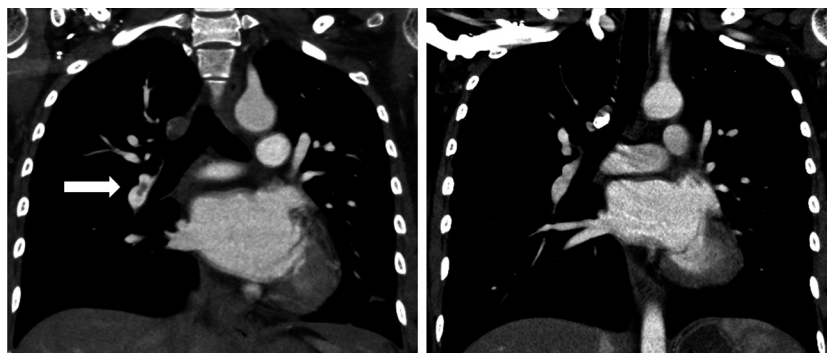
Lung CT images on postpartum day 1 (left) and 10 (right). An arrow indicates thrombus in a lower lobe branch of the right pulmonary artery. The thrombus was not detected with CT on postpartum day 10.
